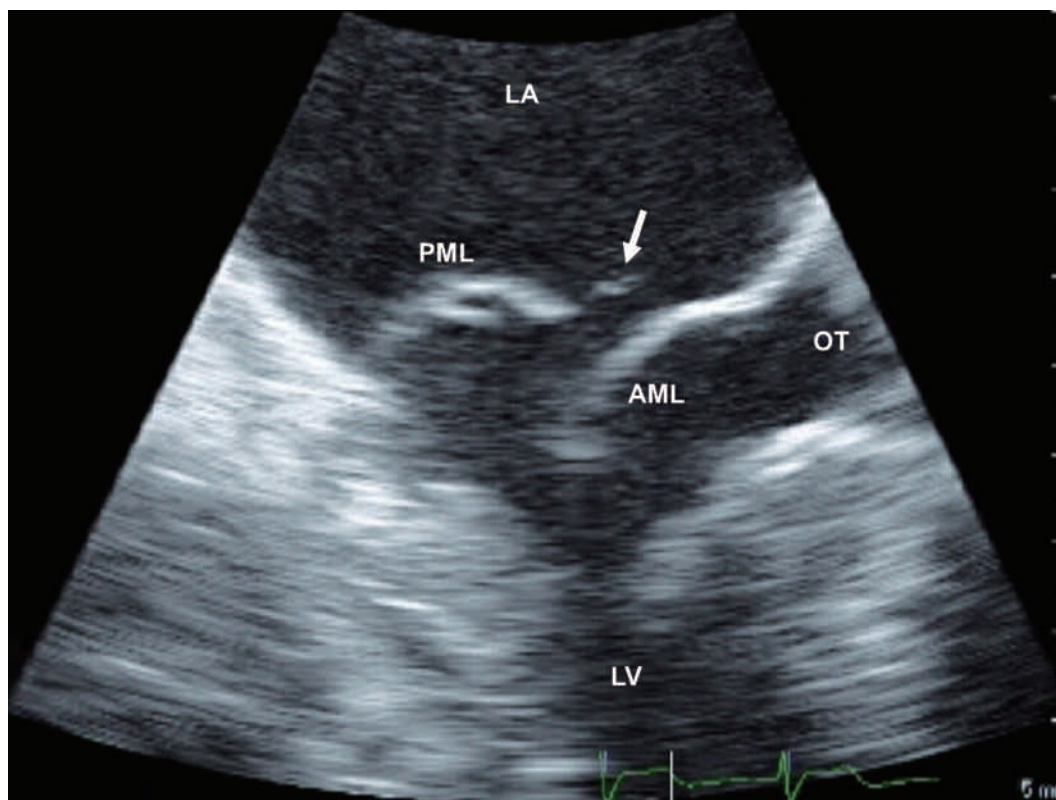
Transesophageal echocardiogram on systole four years after the first presentation. A torn chorda (arrow) is attached to the tip of the prolapsed posterior mitral leaflet. AML=anterior mitral leaflet; LA=left atrium; LV=left ventricle; OT=outflow tract of left ventricle; PML=posterior mitral leaflet.
